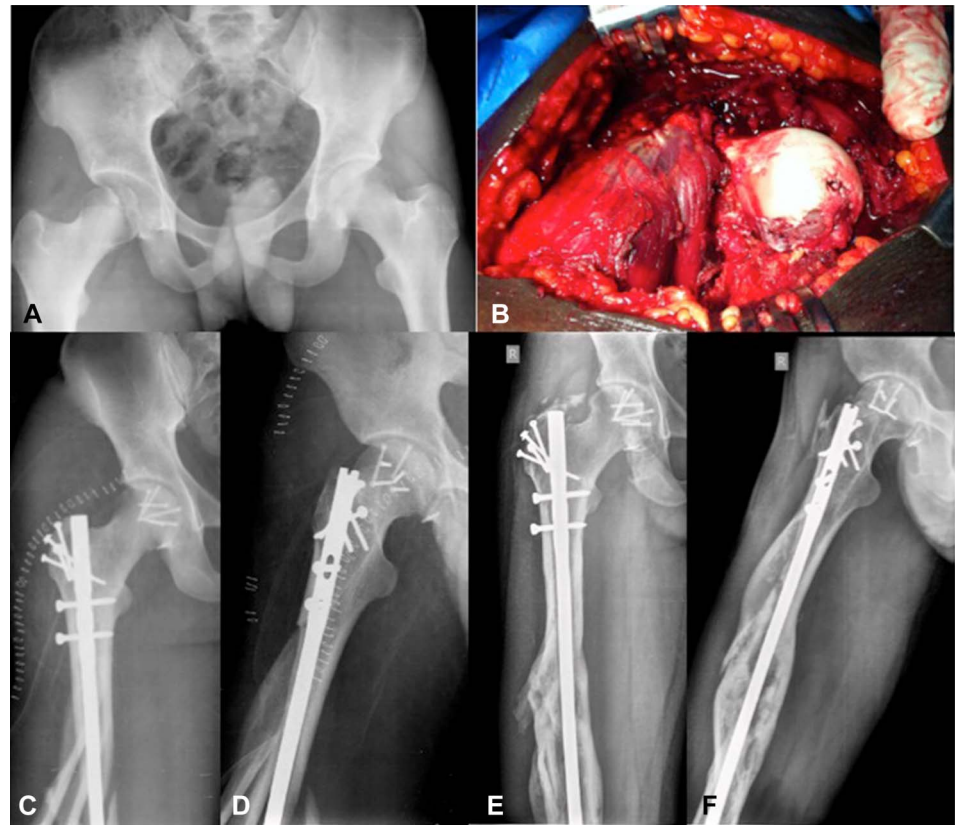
A, Type II Pipkin injury in a 23-year male patient demonstrating an incongruent joint after closed reduction. B, Intraoperative image shows extensive chondral damage. C, D, Immediate postoperative x-rays after internal fixation and labral repair showing a congruent hip joint. E, F, Thirty months follow up x-rays show evidence of degenerative hip joint and fixation.
